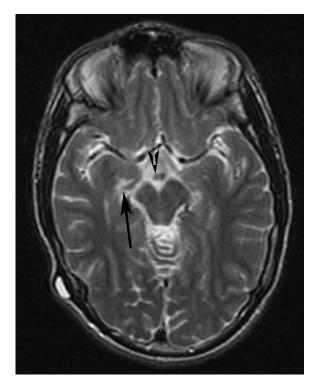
Axial T2-weighted MRI (4500/118) demonstrates asymmetric atrophy of the right mamillary body (arrowhead) and right amygdala (arrow) with compensatory dilatation of the temporal horn of the right lateral ventricle.
